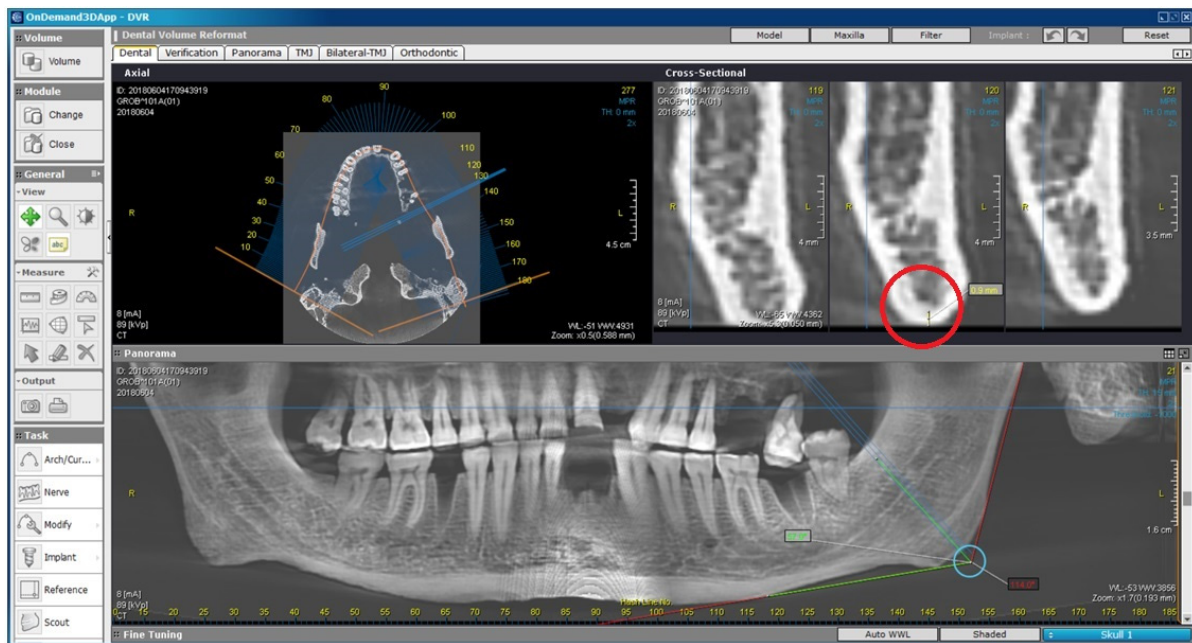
Measurement of the gonion index (GI) on the CBCT scan. The GI was measured along the line bisecting the angle formed by the tangent parallel to the inferior edge of the mandible and the tangent parallel to the posterior edge of the ramus of the mandible (circled in blue). The thickness of the mandibular cortex at the mandibular angle was measured in the sagittal projection (circled in red).
